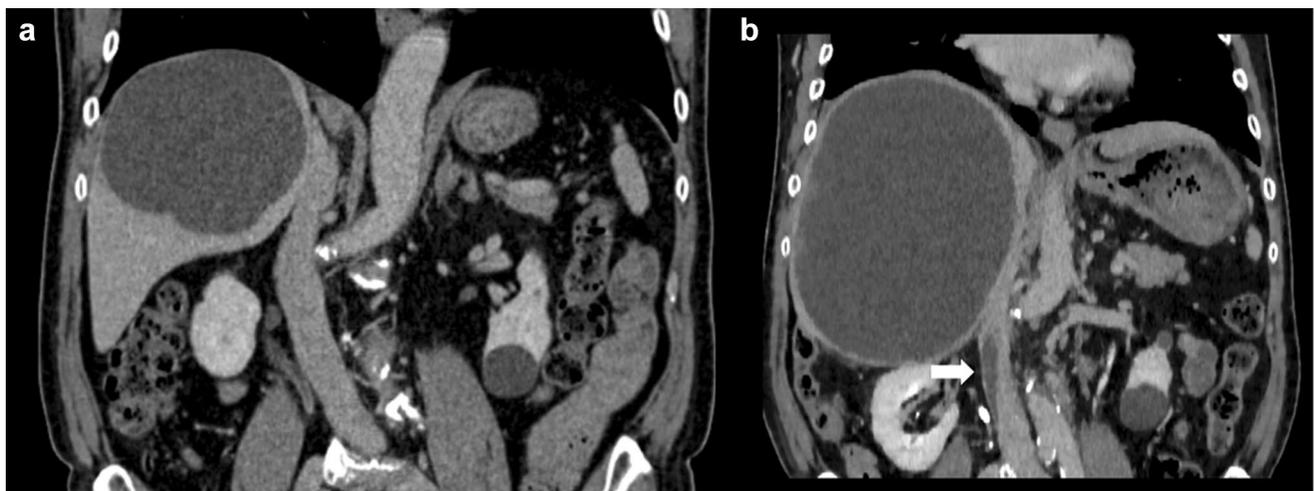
Enhanced computed tomography. Enhanced computed tomography (CT) shows a cyst in the right liver lobe, 90 mm in diameter at 18 months before hospitalization (a). Enhanced CT shows a 300-mm
